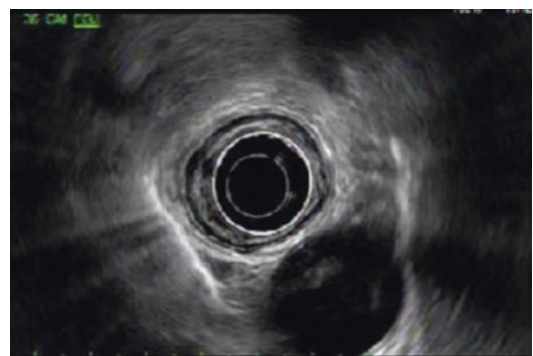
Endoscopic ultrasound image of a T1a adenocarcinoma, with the lesion confined to the mucosal layer
